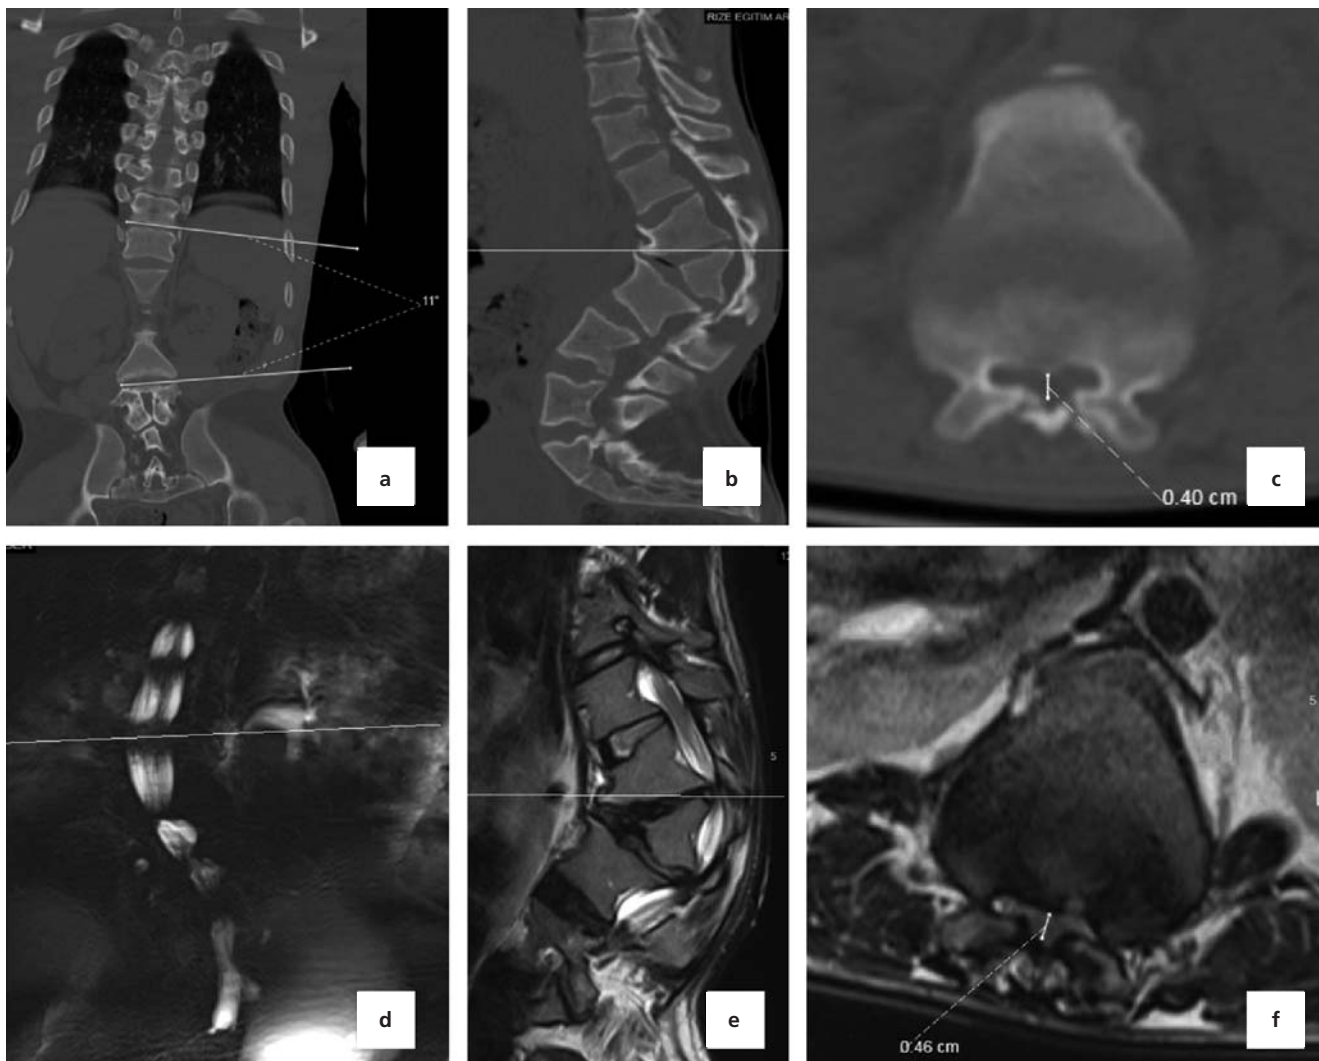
(a-d) Scoliosis is observed in myelo MR and CT section. (b-e) Anterior wedged vertebra on level L2 of the lumbar vertebrae is observed in sagittal CT and MR sections in the 35-year-old male patient (Type 1 deformity). (f) The diameter of the spinal canal decreased to 4 mm at the kyphosis segment in axial CT and MR sections.
